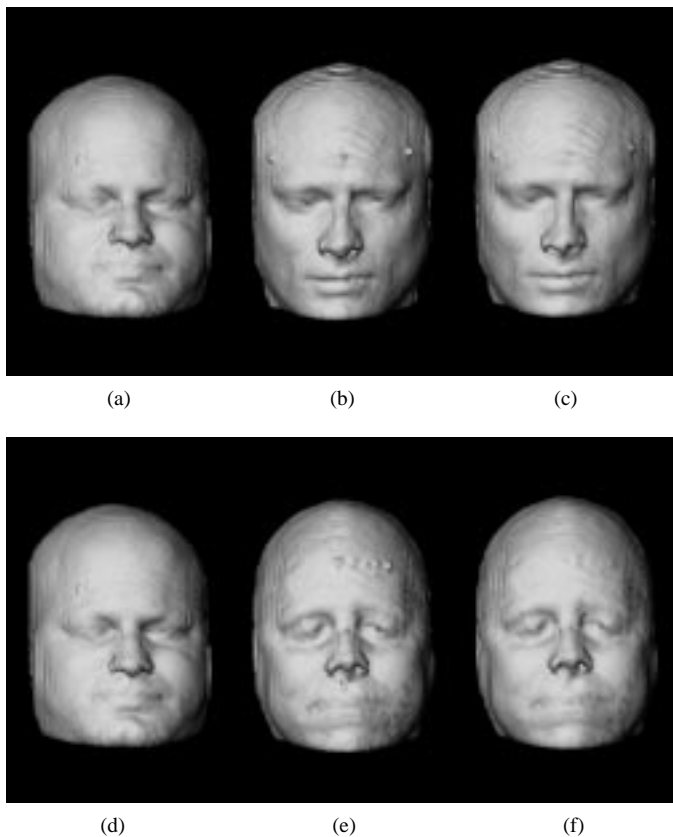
Three-dimensional MRI-MPRAGE head matching. Surface rendering of the MPRAGE (a) template, (b) target data sets, and (c) 3-D fluid deformation of the template to the target; (d)–(f) same as (a)–(c) for second individual.
